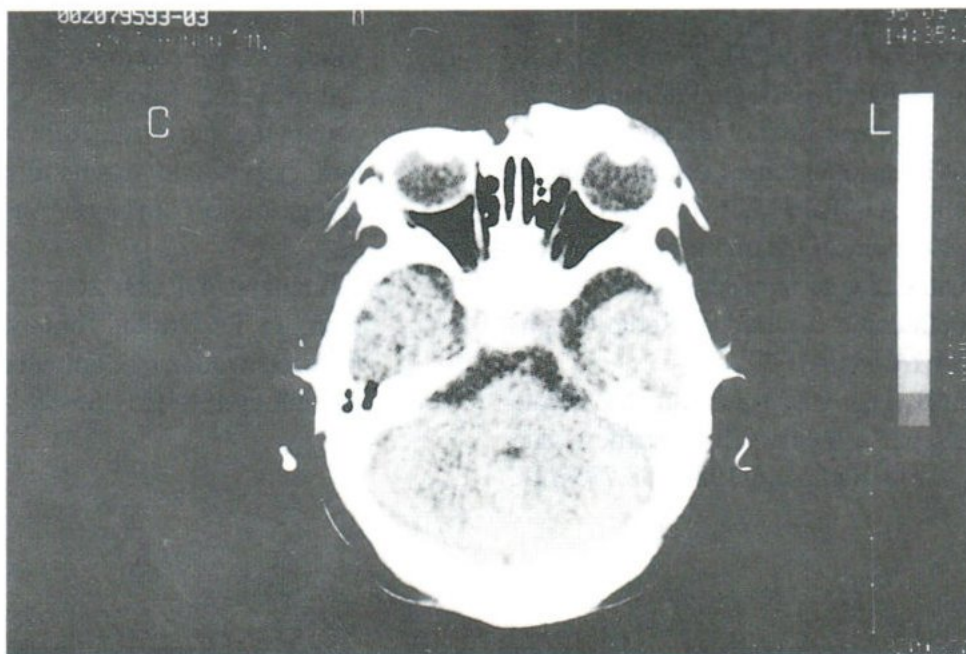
Capillary Hemangioma: CT scan of 2-month-old boy shows lobulated, markedly enhanced extraconal mass.
